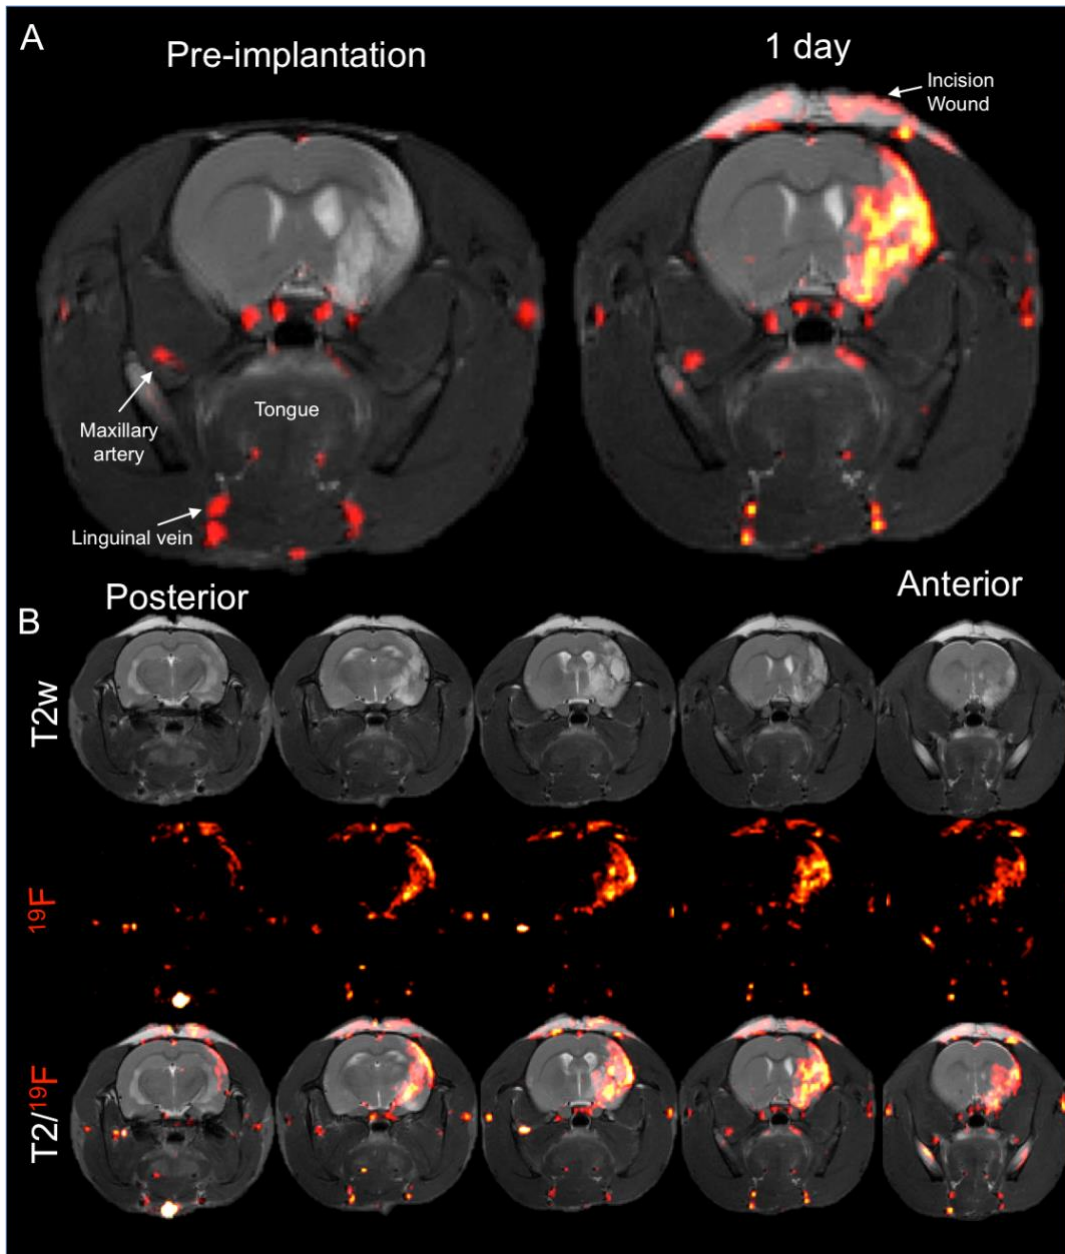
Infiltration of PFCs after ECM implantation as detected by in vivo ^{19}F MRI.
